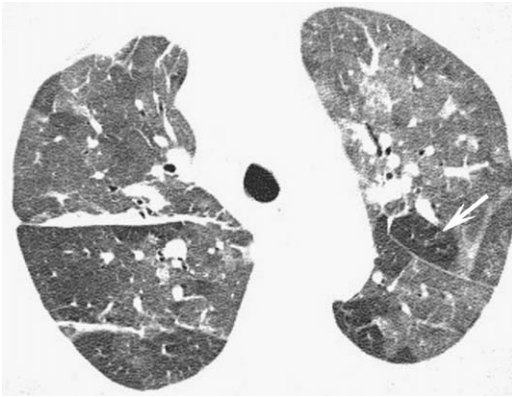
Mixed infiltrative and obstructive pathology affecting the lung: the head-cheese sign. Axial HRCT image in a patient with hypersensitivity pneumonitis shows a combination of ground-glass opacity, normal lung, and mosaic perfusion (*arrow*) on the same inspiratory image.
